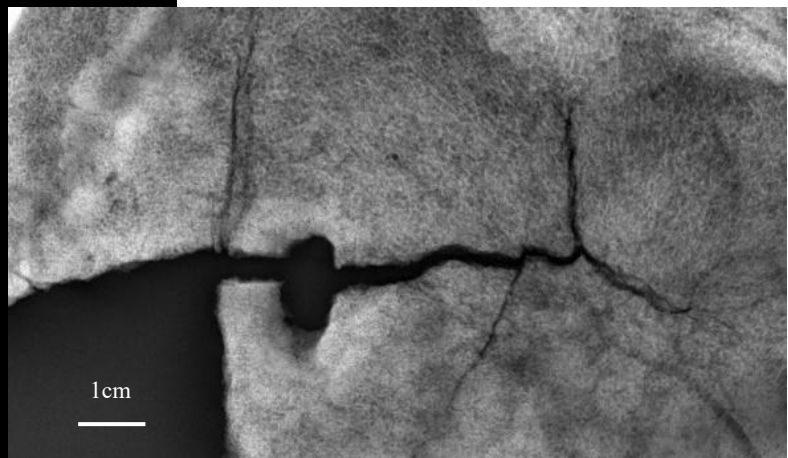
Lateral radiograph from the inside of the skull from SEP 33, zoomed on the lesion. The denser remodeling is visible as increased radiographic brightness. Collège Claude Monnet, Magny-en-Vexin, excavation of 1998
